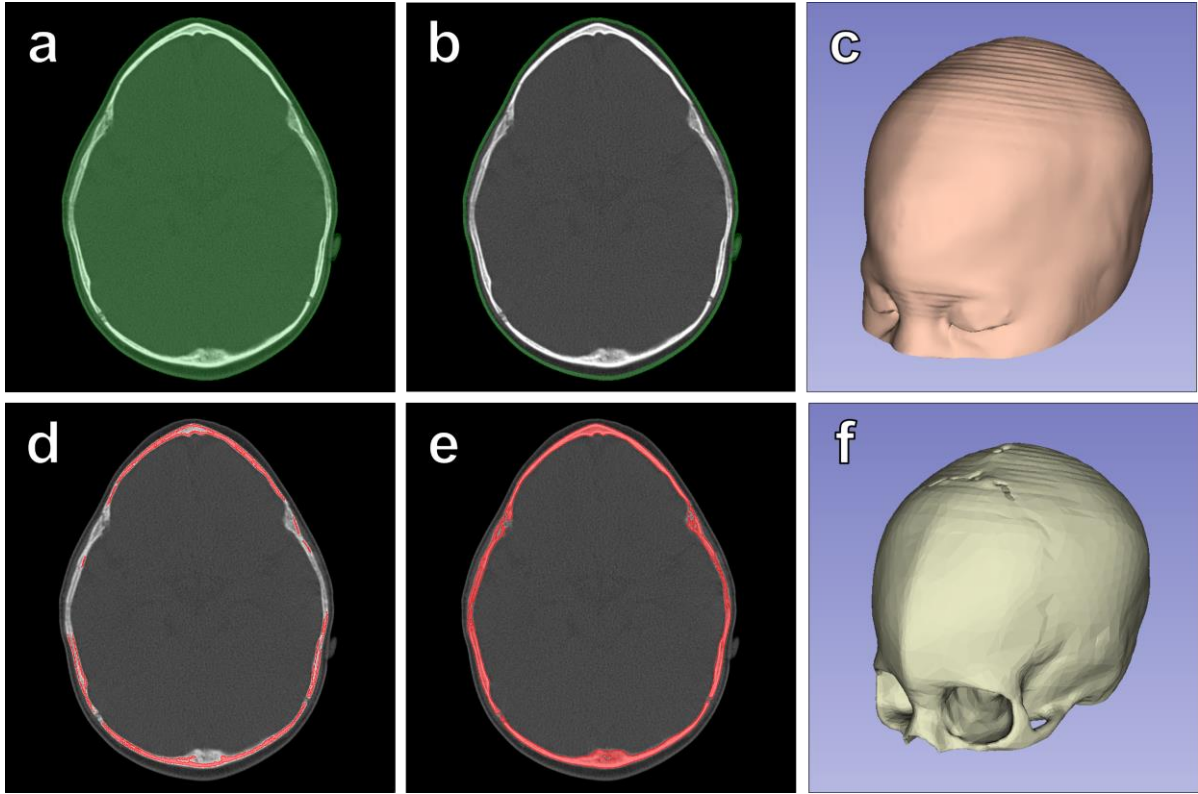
Segmentation of skin and bone from preoperative CT scan of subject 1. (a) Segmentation of skin tissue surface using Otsu thresholding. (b) Extraction of the outer surface of the segment. (c) 3D model of skin tissue. (d) Initialization of bone segmentation using global thresholding. (e) Segmentation of bone tissue using region growing. (f) 3D model of bone tissue.
